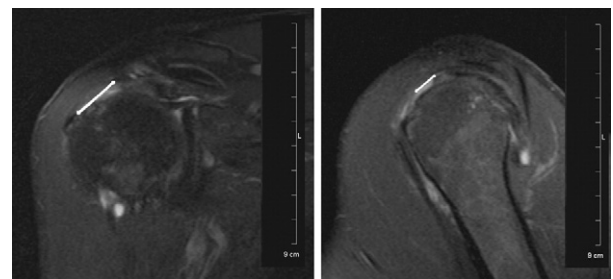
Clinical example of a type 2, longitudinal tear on MRI with maximal coronal length (left) greater than sagittal width (right).
